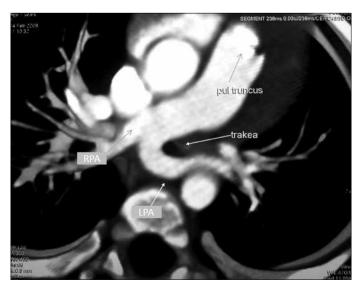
Multislice CT image shows the LPA originating from the posterior aspect of the RPA and encircling the trachea CT- computed tomography, LPA- left pulmonary artery, RPA- right pulmonary artery
